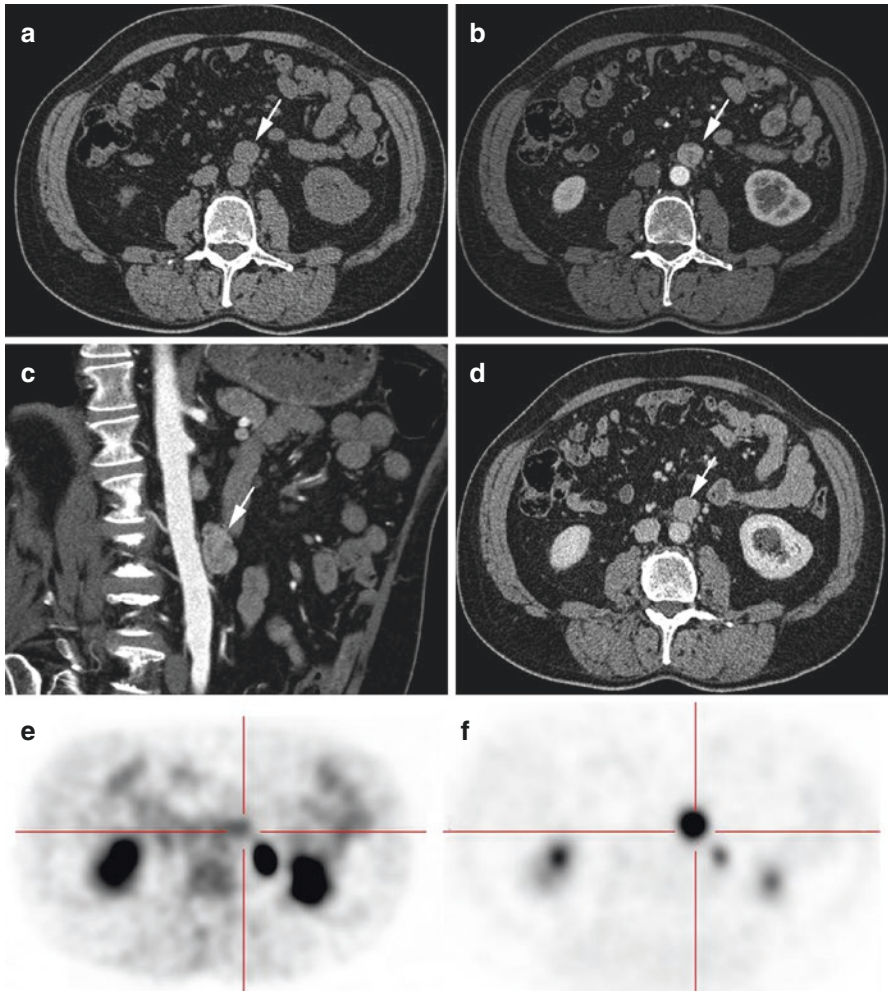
Sporadic extra-adrenal paraganglioma. CT scan revealed a solitary pre-aortic mass with a rapid and marked contrast enhancement and a slow washout pattern suspected of paraganglioma. ^{18}F -FDG PET was slightly positive, but ^{18}F -FDOPA PET was pathognomonic for PGL. (a) Unenhanced CT, 40 HU; (b) arterial contrast-enhanced CT, 130 HU; (c) arterial contrast-enhanced CT (reconstruction); (d) portal-phase contrast-enhanced CT, 80 HU; (e) ^{18}F -FDG PET, moderate tumor uptake ($\text{SUV}_{\text{max}}=2.5$); and (f) ^{18}F -FDOPA PET, high tracer uptake ($\text{SUV}_{\text{max}}=8.5$). Pathological analysis found a typical paraganglioma
